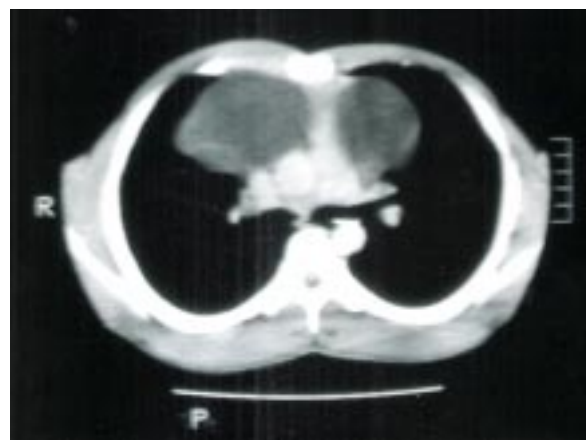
CT chest showing a large nonenhancing cystic lesion in the anterior mediastinum with hypodense and hyperdense areas.
